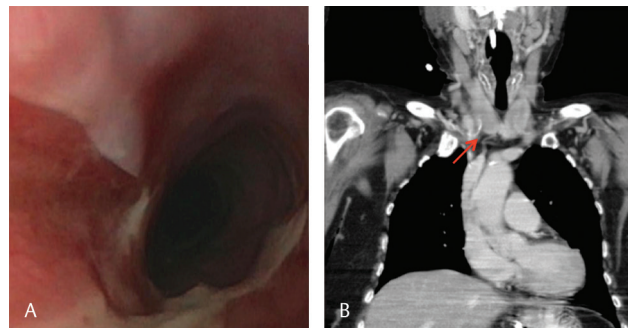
(A, B) A control EGD and a CT scan, which was performed 11 days after perforation confirmed closure of the leak with complete release of pneumomediastinum 11 days after perforation.
